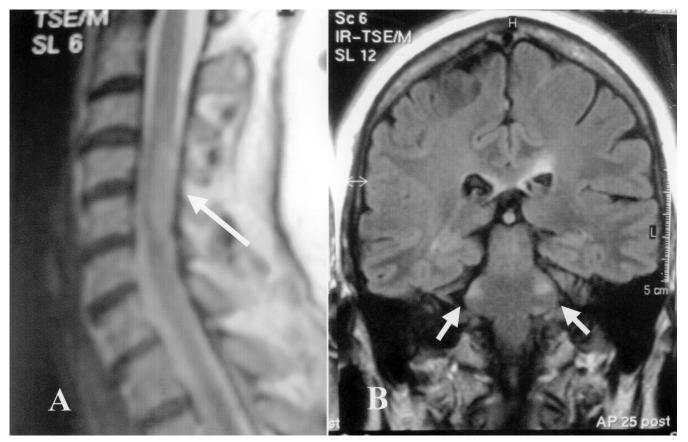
Magnetic resonance image showing hyperintense lesions in T2 consistent with demyelinating lesions at the cervical spinal cord (A, arrow) and brain stem at the level of cerebellar peduncles (B, arrows).
